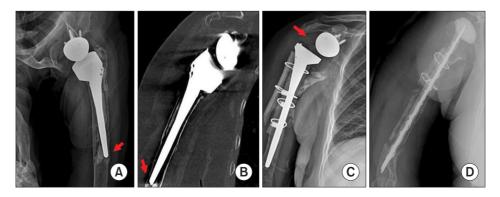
(A, B) In a 73-year-old woman, the X-ray and computed tomography scan images showed a periprosthetic fracture (arrows) due to humeral stem loosening. (C) In the revision surgery of humeral stem loosening, the whole humerus allograft was used in the humeral bone defect and also glenohemeral dislocation (arrow) was found. (D) At postoperative 7 months, glenohumeral dislocation with infection developed and then prosthesis with antibiotic-loaded acrylic cement insertion was performed after failed conservative management.
